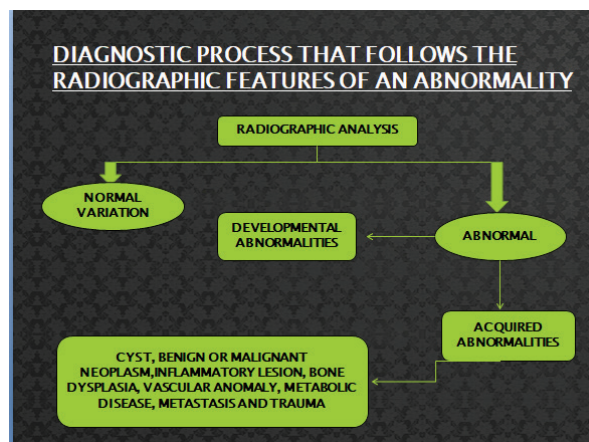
Diagnostic process that follows the radiographic features of an abnormality
